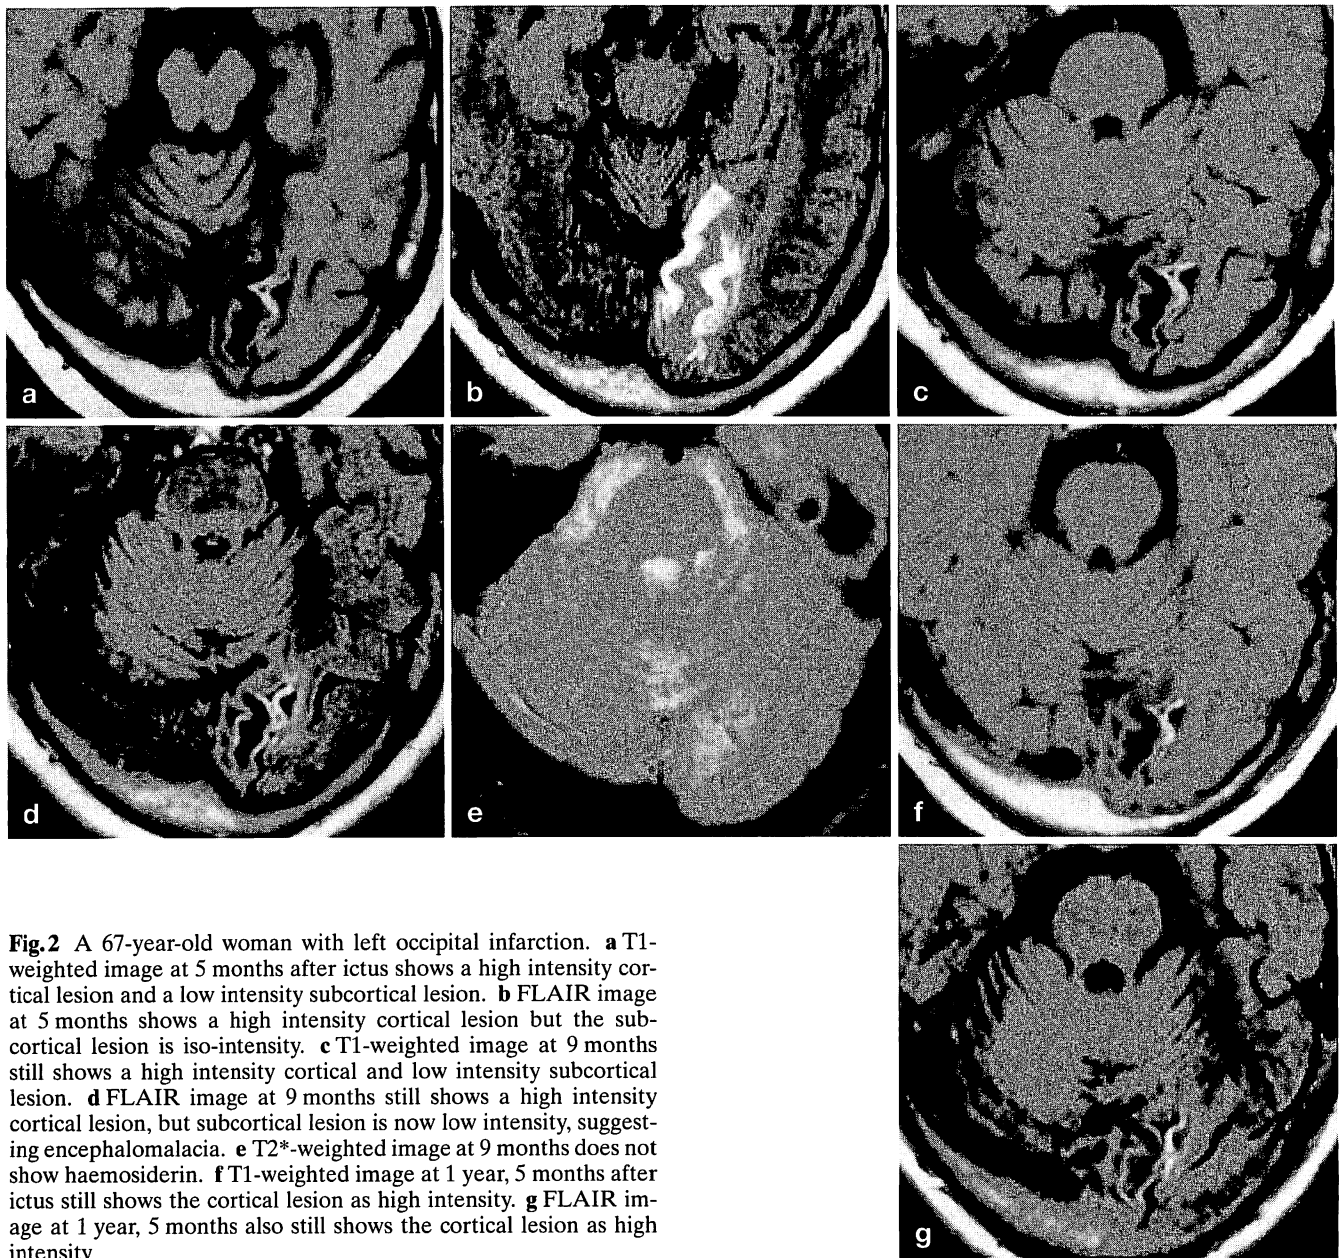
A 67-year-old woman with left occipital infarction. a T1-weighted image at 5 months after ictus shows a high intensity cortical lesion and a low intensity subcortical lesion. b FLAIR image at 5 months shows a high intensity cortical lesion but the subcortical lesion is iso-intensity. c T1-weighted image at 9 months still shows a high intensity cortical and low intensity subcortical lesion. d FLAIR image at 9 months still shows a high intensity cortical lesion, but subcortical lesion is now low intensity, suggesting encephalomalacia. e T2*-weighted image at 9 months does not show haemosiderin. f T1-weighted image at 1 year, 5 months after ictus still shows the cortical lesion as high intensity. g FLAIR image at 1 year, 5 months also still shows the cortical lesion as high intensity
